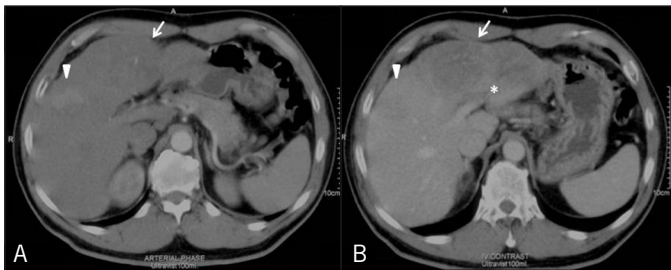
(A) Contrast-enhanced abdominal CT showing liver cirrhosis, an ill-defined, arterial-enhancing heterogeneous isodense to hypodense lesion (arrow), and (B) increased enhancement in the left lobe of the liver on venous phase with central necrosis (arrow) and left main portal vein thrombosis (asterisk).
